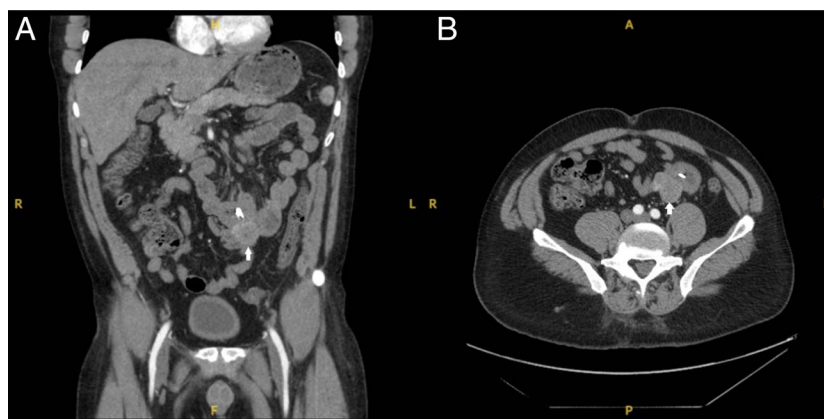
A computed tomography image of the abdomen and pelvis with angiography showing multiple surgical clips near the small bowel loops with an adjacent soft tissue mass measuring 3.2 cm. Figure A is a coronal view and B is a transverse view with white arrows pointing towards the mass.
